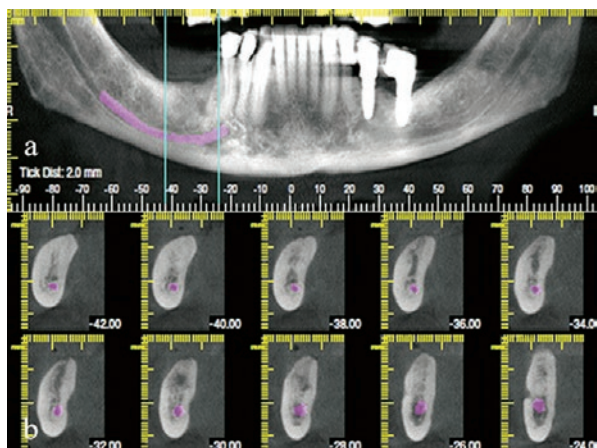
The orthopantomogram and the oblique sagittal reformatted view of the mandible
